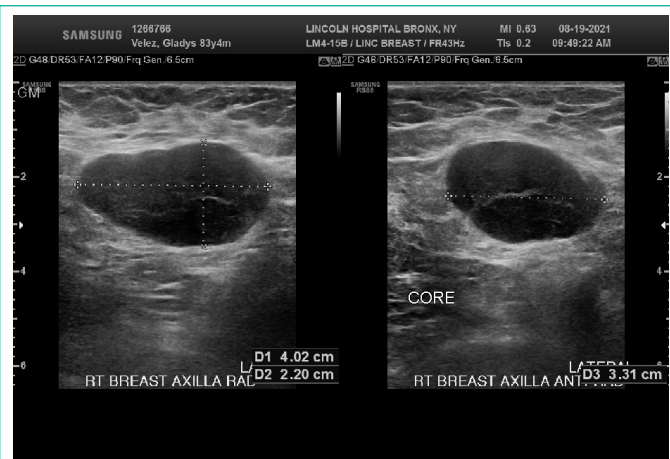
Initial breast Ultrasound.
